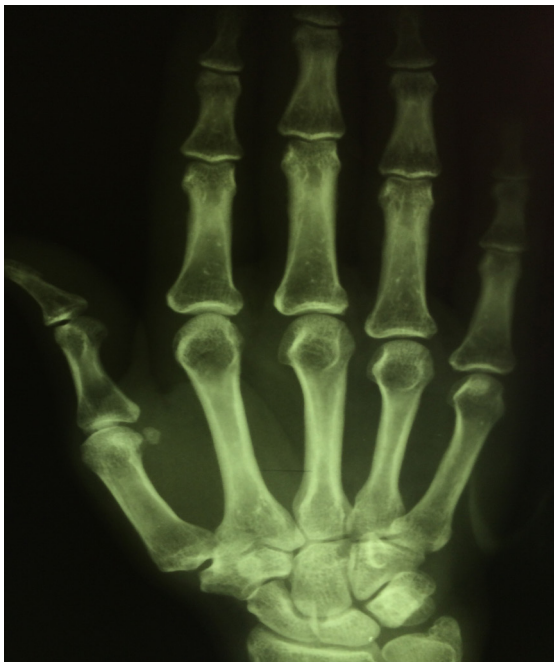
Hand X-ray . No Sing of mass of bone destruction.
